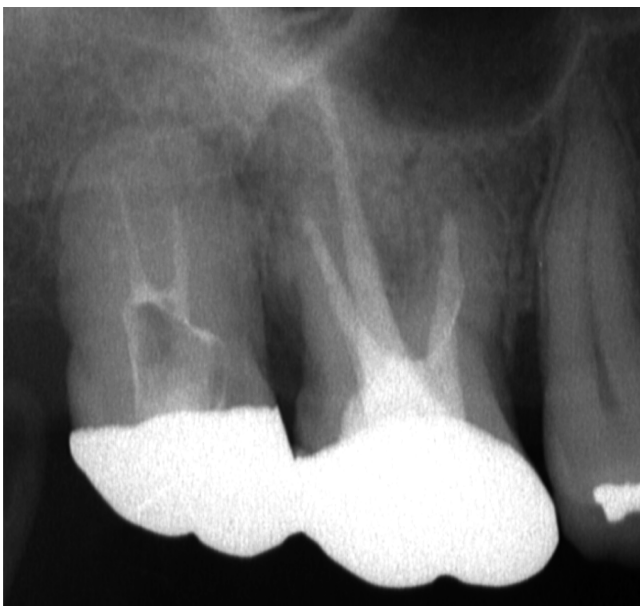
A 3-yr post-treatment conventional intraoral radiograph of the right maxillary molars.
